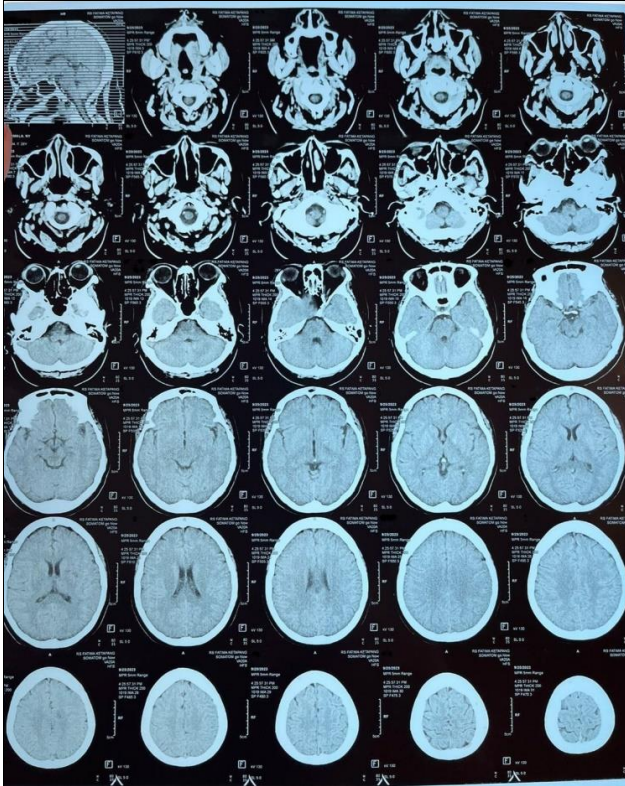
Brain CT with Contrast
